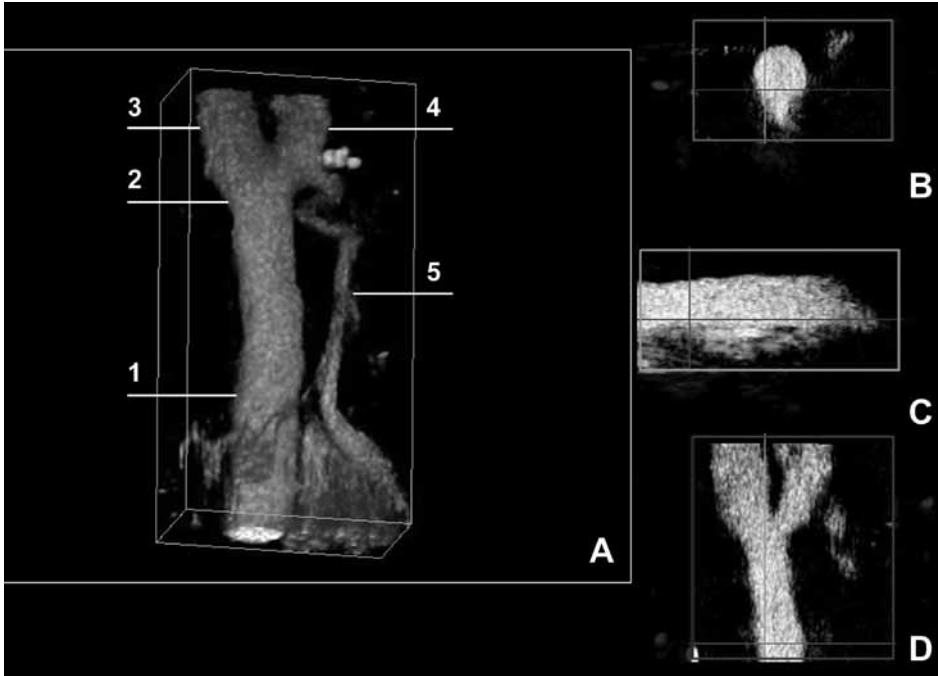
Contrast-enhanced 3D ultrasound scan using volume rendering (A) and multiplanar reconstruction demonstrating the transversal (B), sagittal (C), and coronal plane (D), reconstructed from a freehand sweep of the carotid artery (QLAB; Philips Healthcare, Best, The Netherlands). The volume rendering image shows the common carotid artery, (1) carotid bifurcation, (2) proximal internal, (3) and external carotid artery. (4) The superior thyroid artery (5) branches from the external carotid artery and descends to the thyroid gland.
